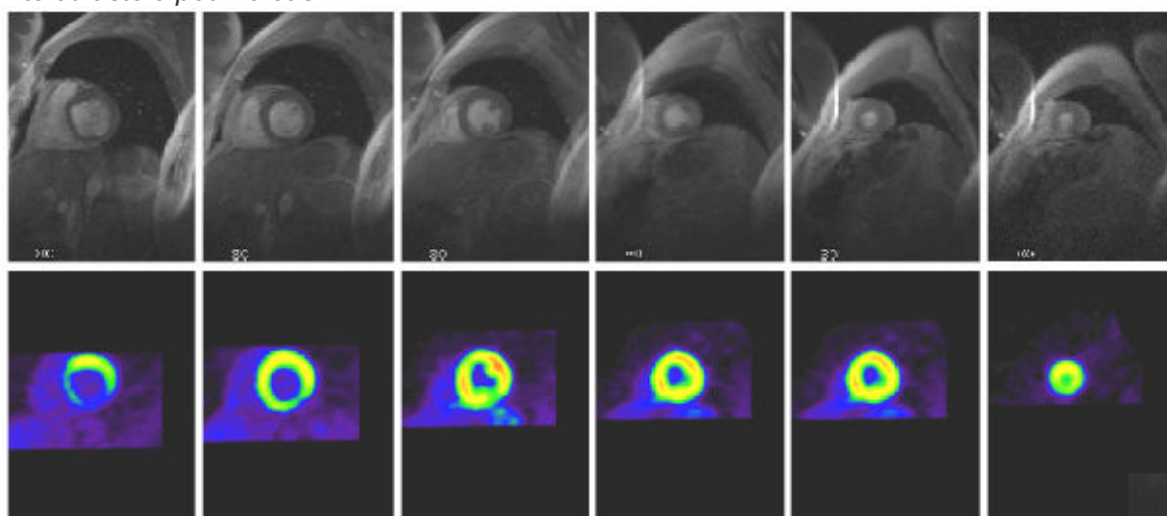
Coupes IRM en petit axe (en haut) recalées à des images TEP 18F-FDG (en bas) en télédiastole pour le cas E1.
